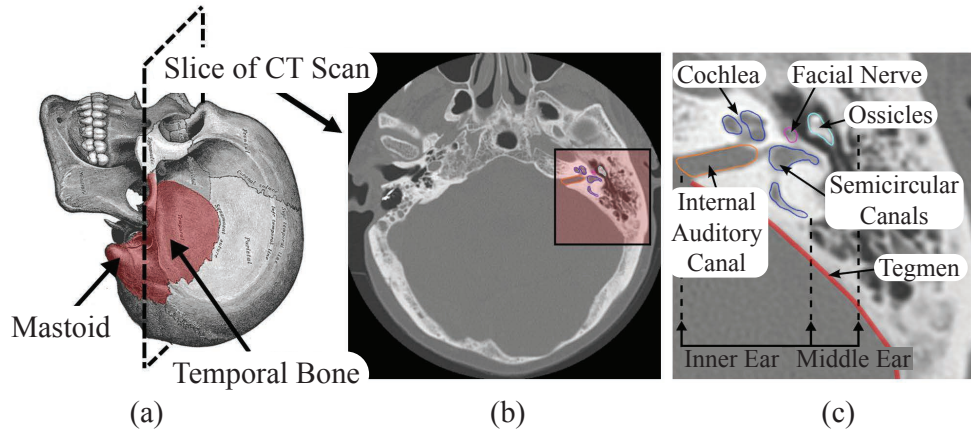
(a) The temporal bone and mastoid region of the skull, (b) a CT slice looking at the various segmented ear structures, and (c) the vital anatomical structures embedded within the mastoid bone.
